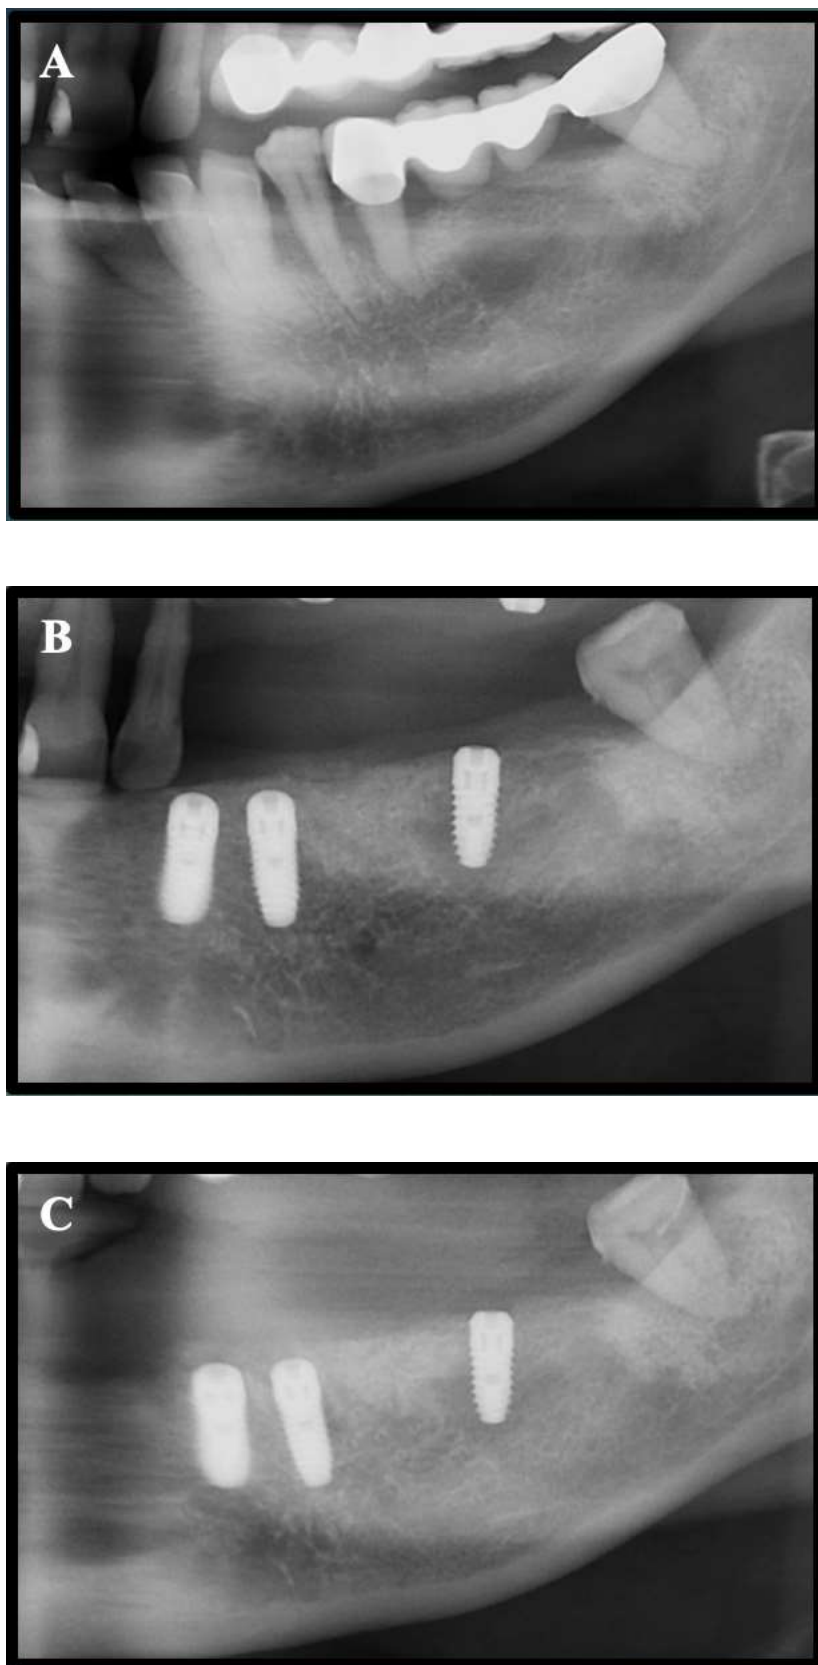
Preoperative (A), postoperative (B), and 4th month postoperative (C) panoramic radiograph of the patient
